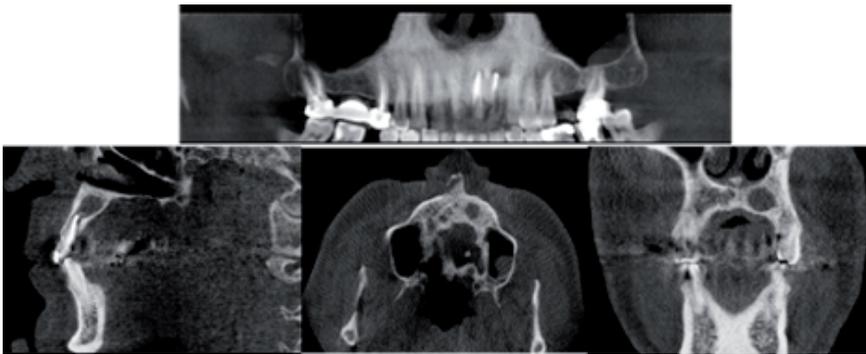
3 years later, a CBCT showing the bone healing in the three planes.
